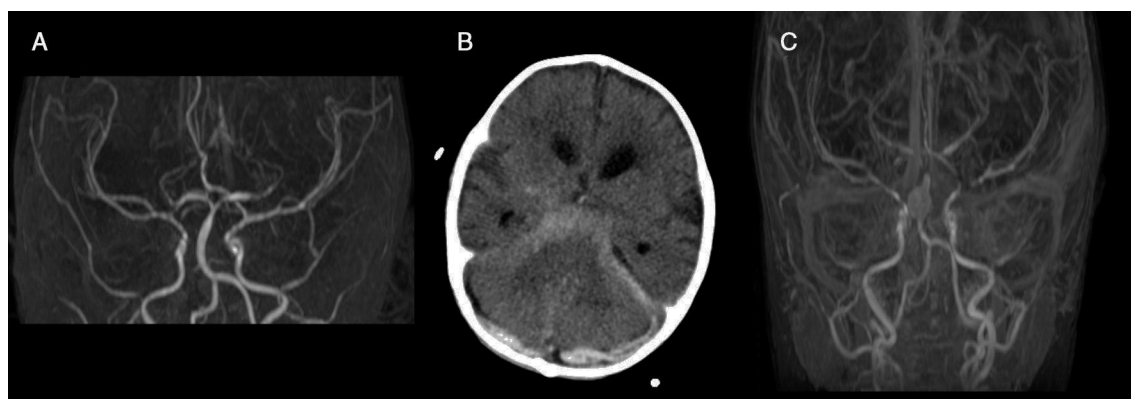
(A) Image of coronal magnetic resonance angiogram: stenosis and dilations (string of bead) in the middle cerebral artery and basilar artery. (B) CT scan: subarachnoid and subdural haemorrhage. (C) Magnetic resonance angiogram with contrast: aneurysm of the basilar artery.
